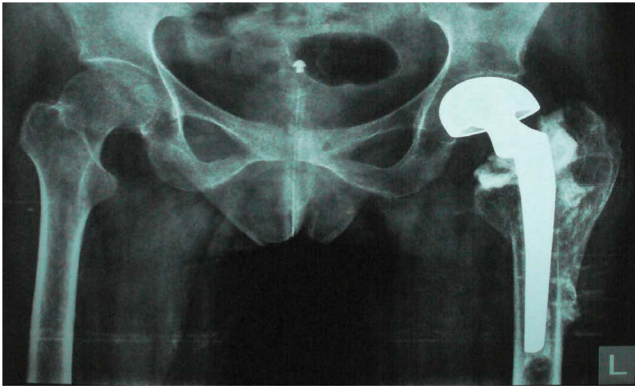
Postoperative x-ray showing stability of the components
